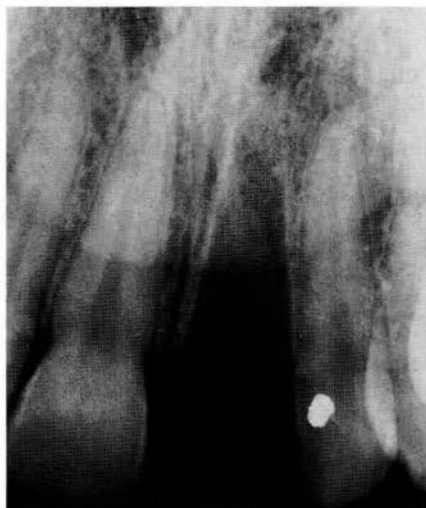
Radiographic picture reveals an empty alveolus, with no apparent fracture of either alveolar bone or adjacent teeth
